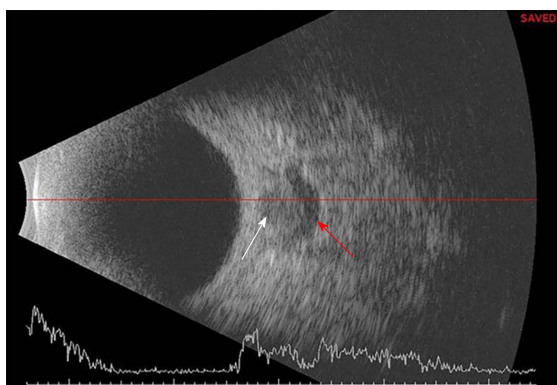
B scan ultrasound picture showing the normal round hypoechoic area of optic nerve (white arrow) with a hypoechoic crescent shaped area (red arrow) depicting “crescent” or “doughnut” sign.
